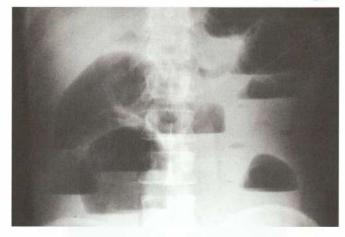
Multiple gas fluid levels—plain X-ray erect abdomen
